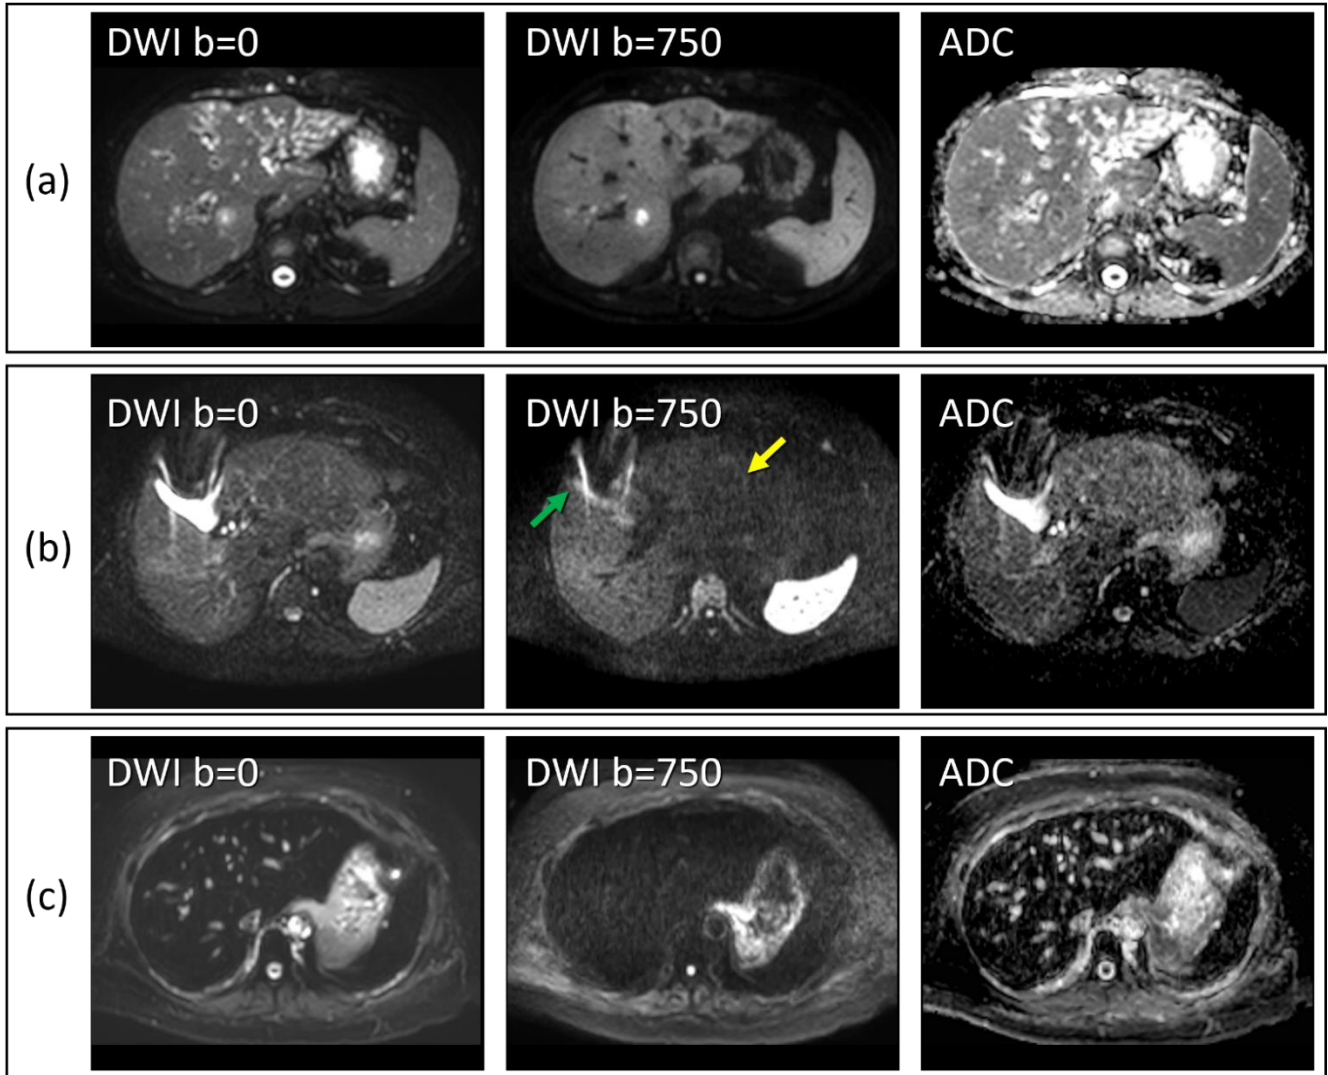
Visual assessment of SNR in liver DWI; (a) an example of good SNR at low and high  $b$ -values; (b) poor SNR particularly in left lobe at  $b=750$  s/mm<sup>2</sup> (yellow arrow) and distortion due to metal (green arrow); and (c) poor SNR at both  $b$ -values where anatomical features of the liver are lost.
